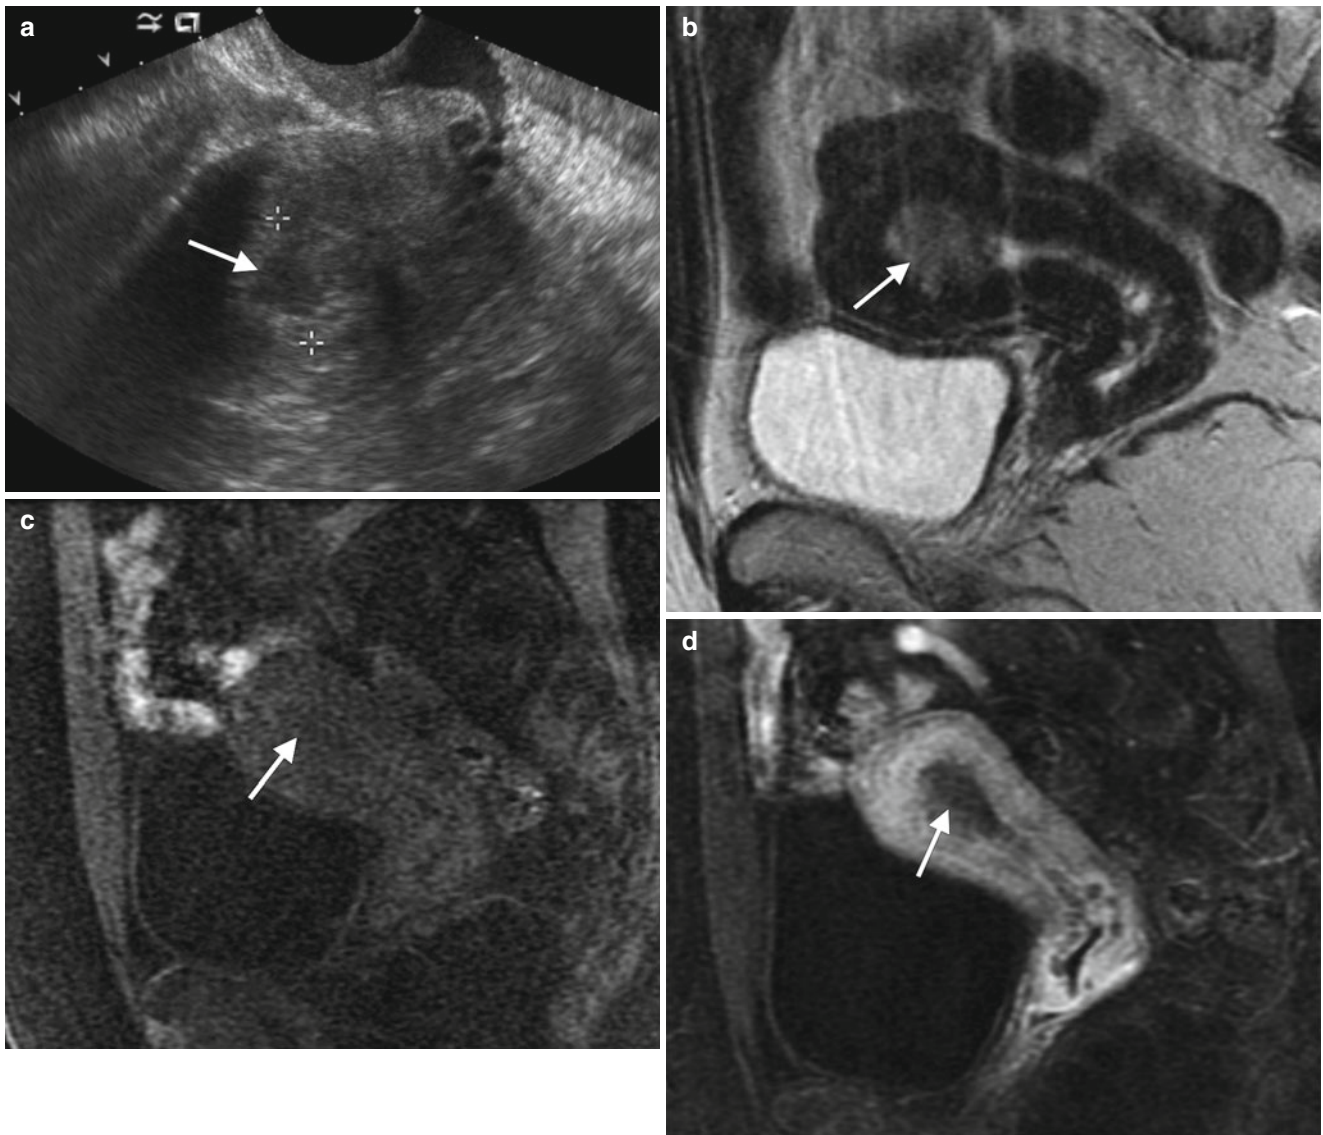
Endometrial thickening is the hallmark of endometrial cancer. This 64-year-old woman with a history of breast cancer underwent a screening gynecologic evaluation, and ultrasound (a) revealed a thickened endometrial cavity (20 mm). A sagittal T2-weighted MR image (b) and sagittal fat-suppressed T1-weighted images before
